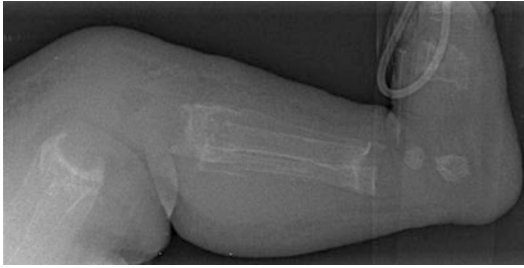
A 25-week gestational age infant presented at 3 months of age with rickets of prematurity due to very low mineral and overall nutritional intake secondary to multiple comorbidities, including necrotizing enterocolitis and bowel resection, with intolerance of adequate enteral and parenteral nutrition volumes. This image demonstrates fraying and cupping of metaphyses as well as fractures. Bowing is not usually evident due to lack of weight bearing (X-ray from the files of Erik A. Imel)
